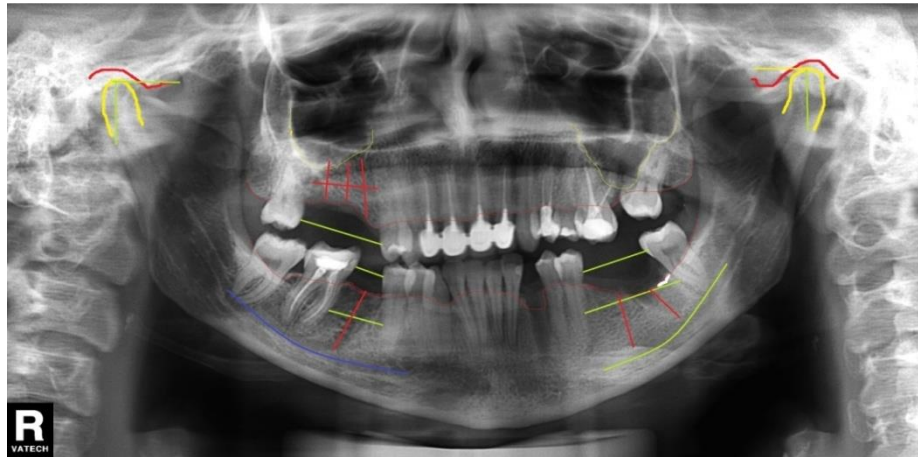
Orthopantomography -2D Analysis of the bone support with identifications:
